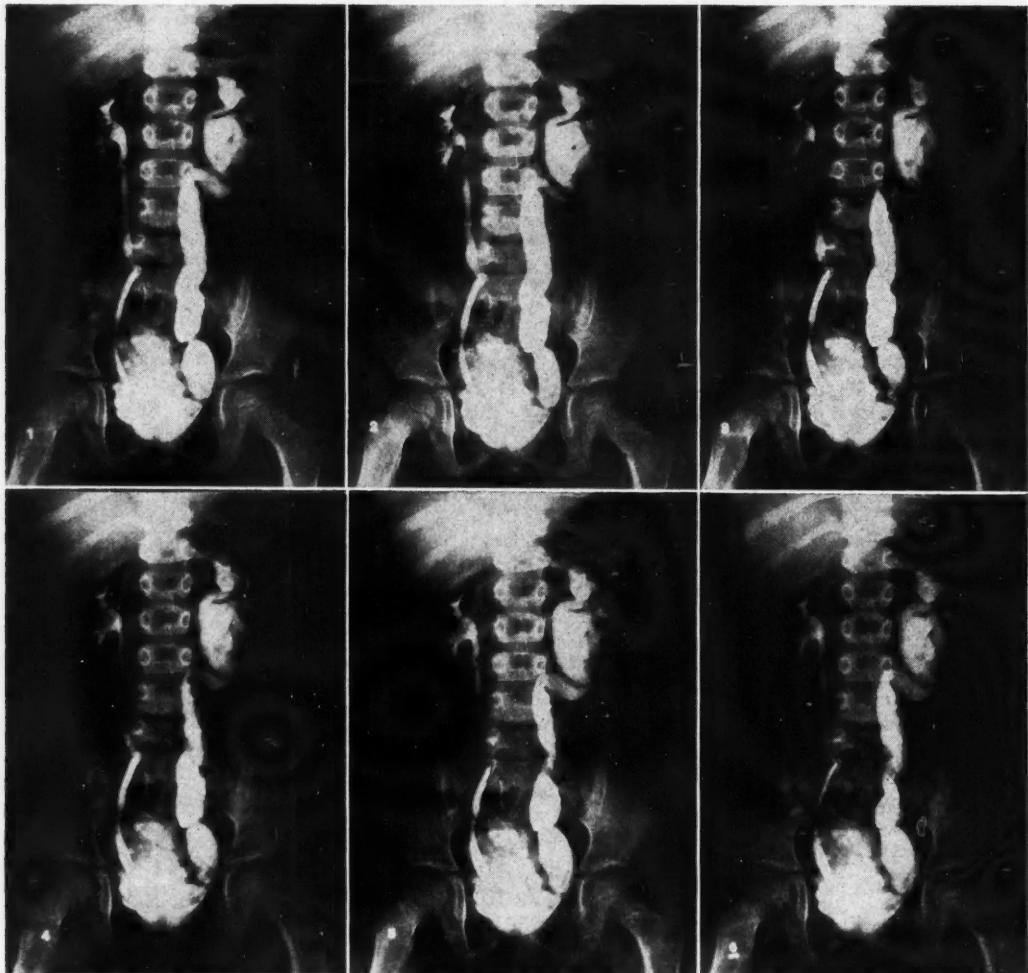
Serial radiographs of the urinary tract of a 5-year-old girl taken with the rapid film-changing technique. Films were taken at 3/4 second intervals. Retrograde urography shows hydronephrosis and hydro-ureter on the left, moderate widening of the lower half of the right ureter, and deformity of the bladder. The rapid changes of peristaltic systole and diastole can be recognized on the radiographs. It is evident that peristaltic waves are present on the diseased (left) side as well as on the more normal (right) side. It is of interest that in addition to circular contractions, longitudinal contractions can also be observed; this is most evident in the lower segment of the left ureter.
